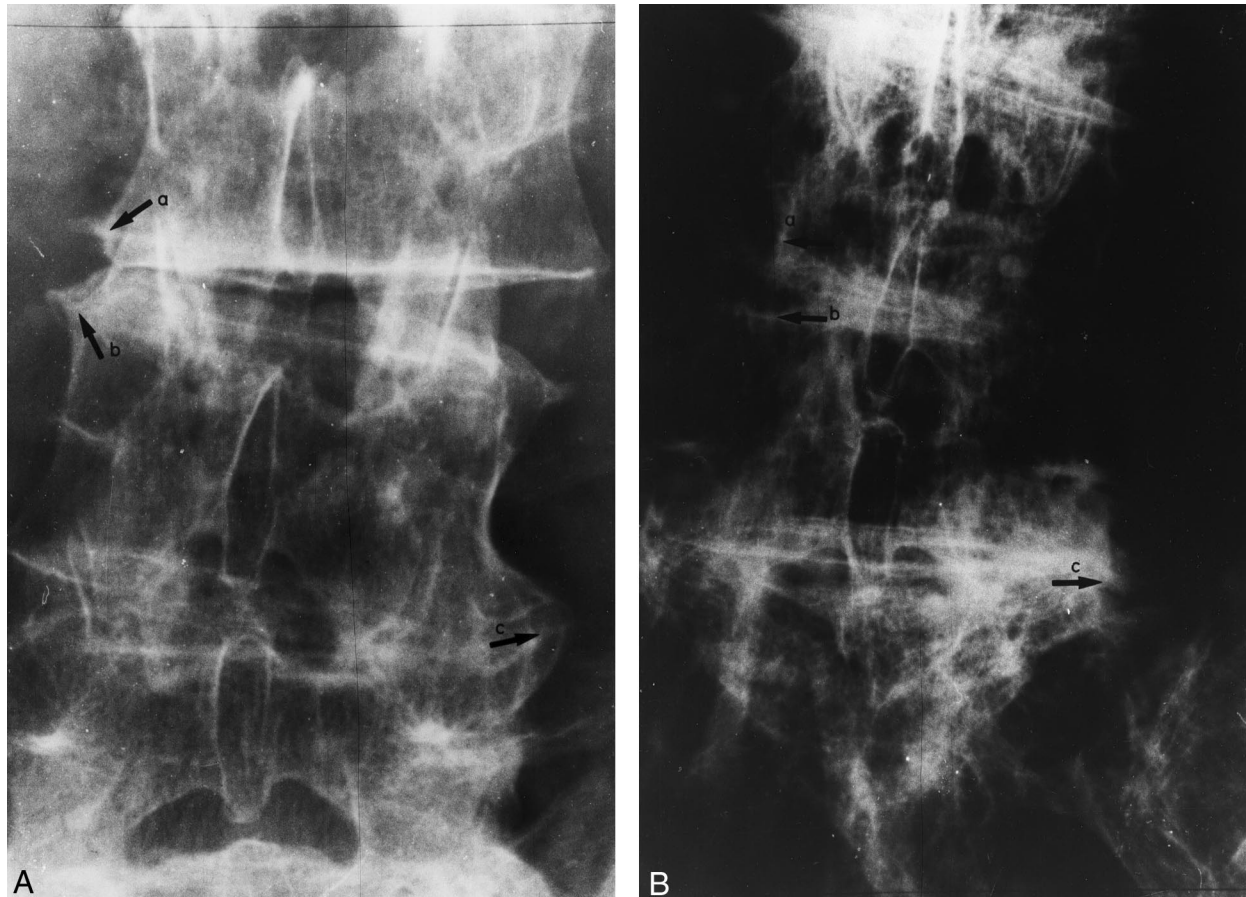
(A) Antemortem radiograph of a 91-year-old man with advanced degenerative changes (a and b, lipping; c, ossification of ligaments). (B) Postmortem radiograph of the same man with similar aging degenerative features. Note also the morphologic similarity of the spinous processes.
